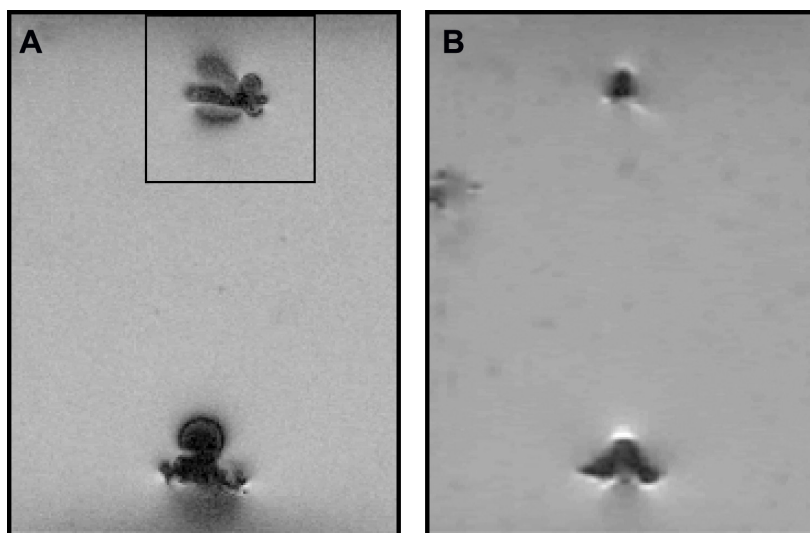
The magnetic field of an iron-labeled cell and its relation to the main magnetic field: the magnetic field is enhanced in the z direction and suppressed in the x direction. (A) FLASH image showing the bloom effect of iron in the MRI image. (B) RARE T_2 -weighted image. (A and B) have FeREX-labeled ESCs (4000 cells) at the top of the image and 5 μl of FeREX solution at the bottom. ESC labeling was accomplished by incubating a monolayer of ESCs (at 80% confluence) for 24 hours in 5% CO_2 at 37°C in a serum-free optimum medium with FeREX and Lipofectamine 2000 at a concentration of 25 μg Fe/mL.
